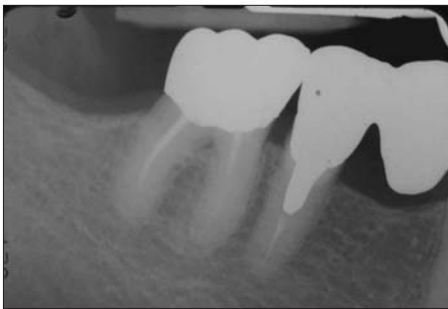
Preoperative periapical radiograph revealing inadequate root canal therapy on tooth No. 30, root canal therapy on tooth No. 29 with large post and is distal abutment for three-unit fixed partial denture and the anterior abutment also is endodontically treated with a post and core.
